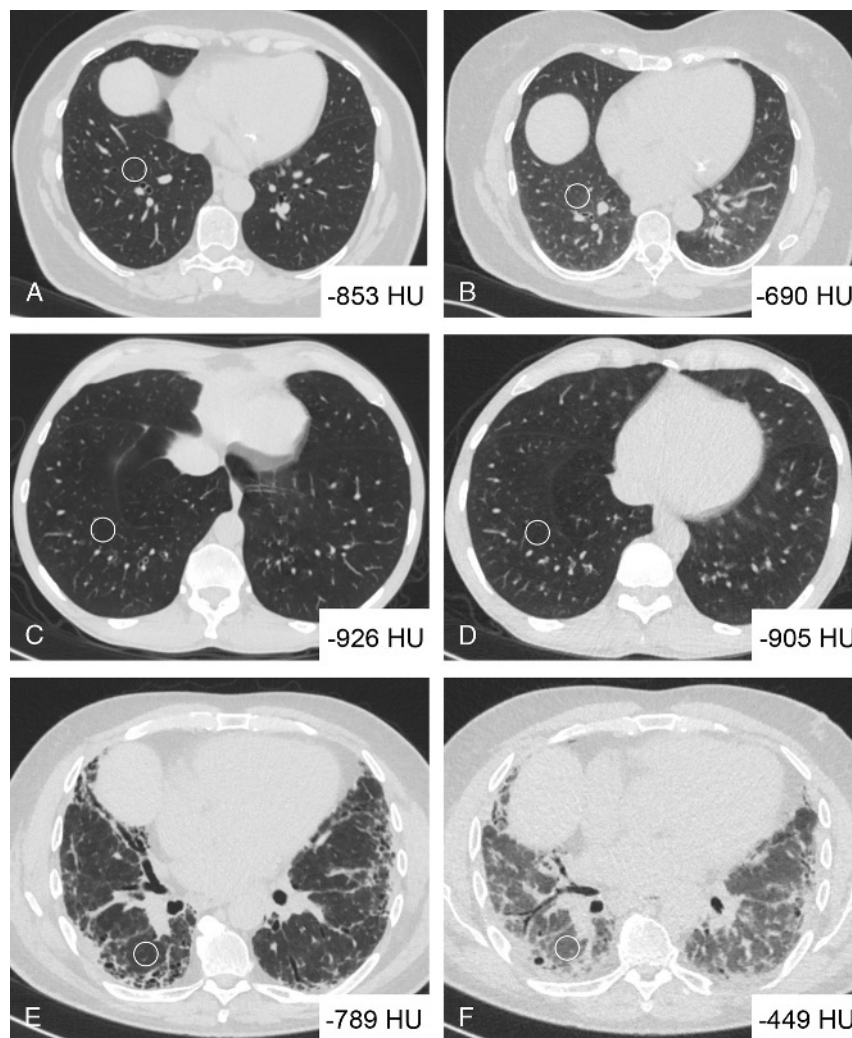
Representative computed tomography density measurements of lower lung lobes in inspiration (left) and expiration (right) in (A and B) a control subject, (C and D) COPD patient, and (E and F) idiopathic pulmonary fibrosis patient. White circle depicts region of interest.
